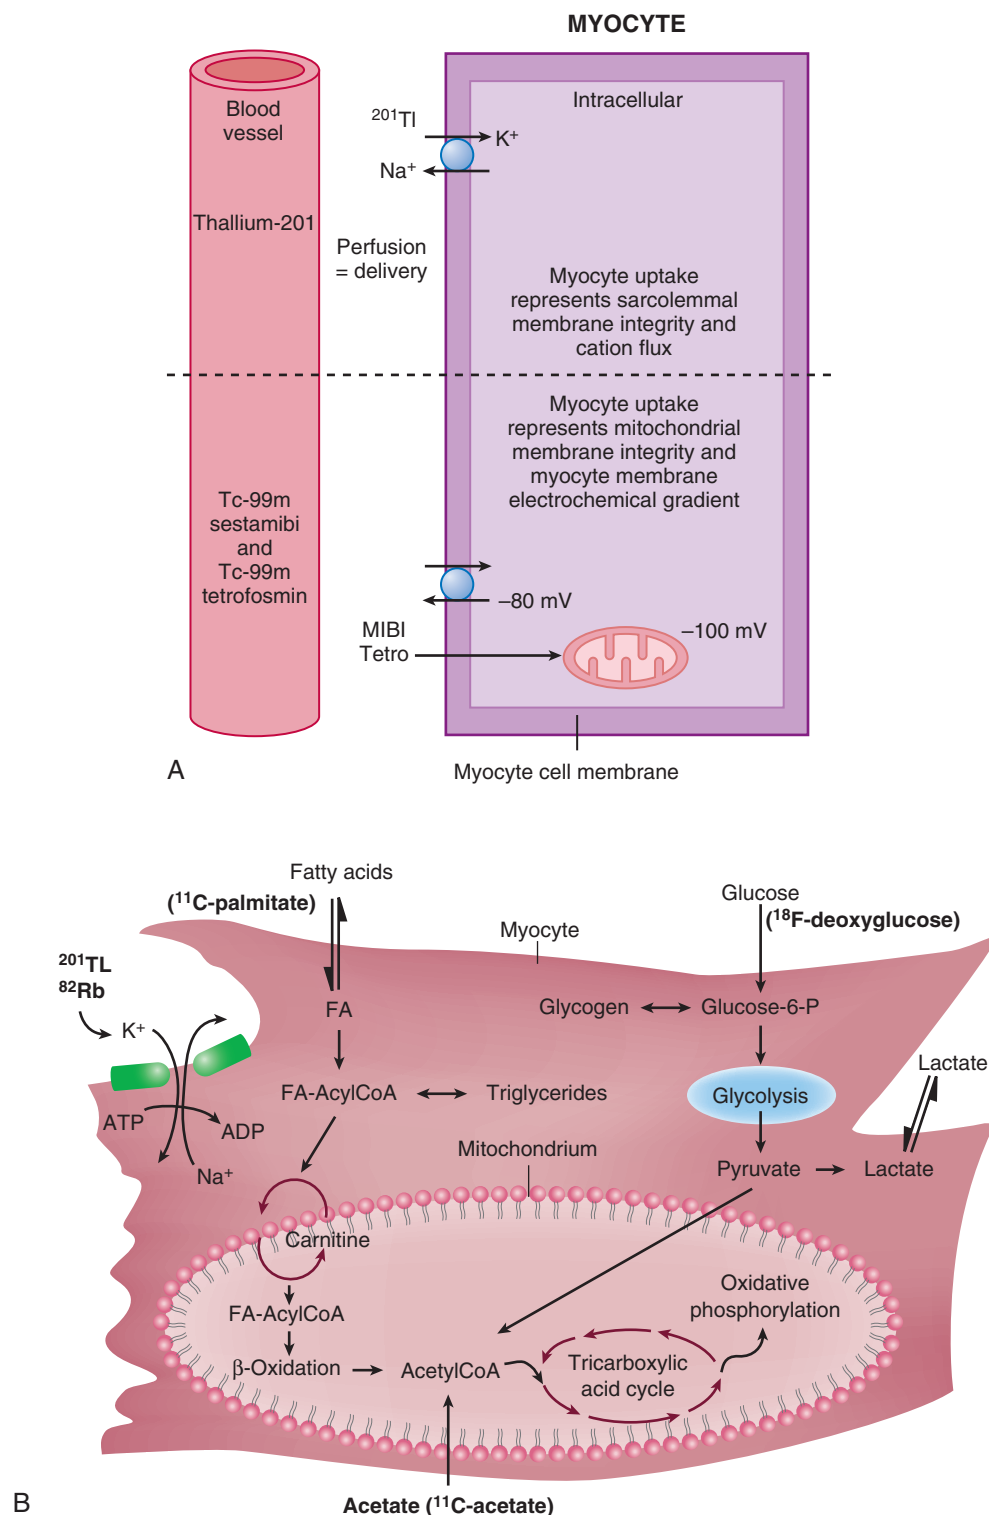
A, Mechanisms of uptake and retention of ^{201}Tl and $^{99\text{m}}\text{Tc}$ perfusion tracers. B, Mechanism of uptake and retention of PET agents tracing perfusion (^{82}Rb) and oxidative and anaerobic metabolism (^{11}C -acetate, ^{11}C -palmitate, and ^{18}F -deoxyglucose). ADP = adenosine diphosphate; ATP = adenosine triphosphate; CoA = coenzyme A; FA = fatty acid; Glucose-6-P = glucose-6-phosphate. (Modified from Dilsizian V: *SPECT and PET techniques*. In Dilsizian V, Narula J, Braunwald E [eds]: *Atlas of Nuclear Cardiology*. Philadelphia, Current Medicine, 2006.)
